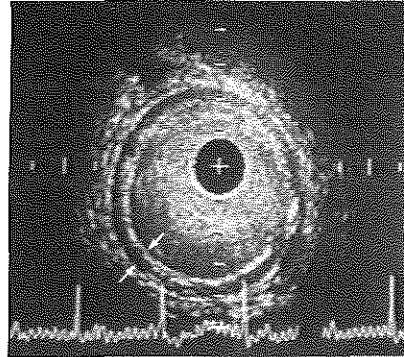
Ultrasonic cross-section obtained in vivo (30 MHz) representing a normal femoral artery. The 3-layered appearance of the arterial wall is similar to that seen in the in vitro study (compare Figures 1 and 4). Media thickness is indicated by arrows. Echogenicity of blood is seen within the arterial lumen (calibration 1 mm).
